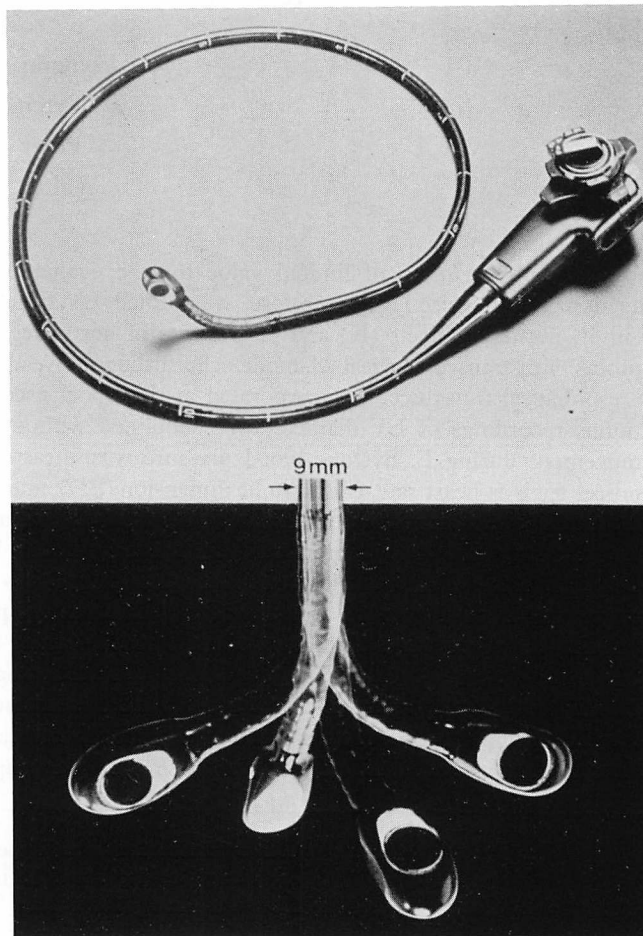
Our newly developed transesophageal ultrasound transducer system for M-mode echocardiograms using a gastroscope.
